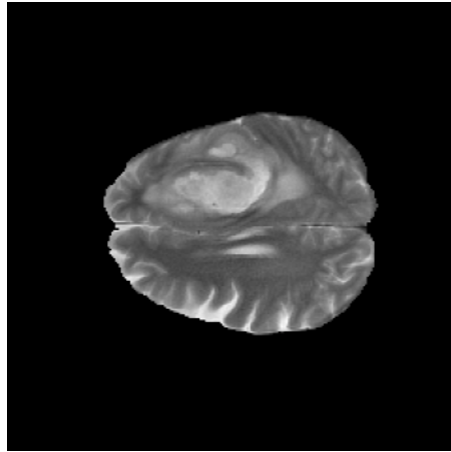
Example of T2-weighted MRI sequence.
